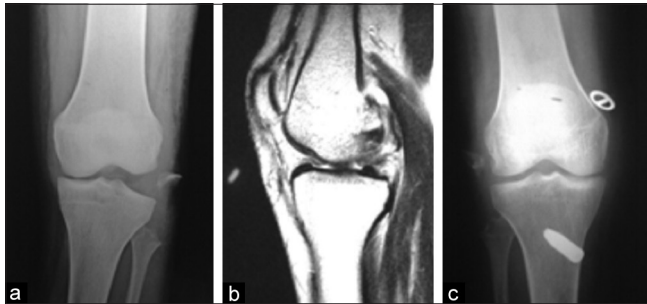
(a) Plain radiographs of left knee (anteroposterior view), showing lateral collateral ligament avulsion (b) MRI of left knee showing anterior cruciate ligament rupture (c) Postoperative plain radiographs of left knee (anteroposterior view), showing posterior cruciate ligament reconstruction done
